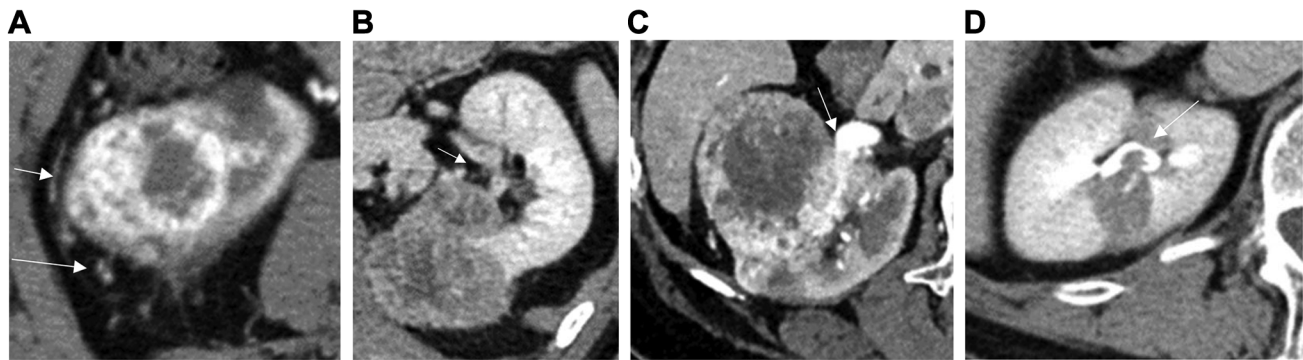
Representative image of each factor on contrast-enhanced computed tomography A) Peritumoral fat invasion: The thickness of Gerota fascia (short arrow) and neo-vessels (long arrow) surrounding the tumor. B) Sinus fat invasion: small hyperdense strands surrounding the tumor (arrow). C) Venous invasion: a filling defect in the intrarenal vein, and the dilation of the vein adjacent to the tumor (arrow). D) Urinary tract invasion: a filling defect in the urinary tract (arrow).
